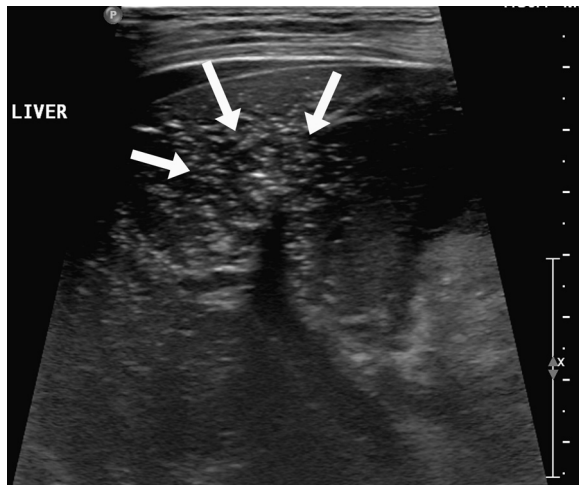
Transverse sonogram demonstrates a heterogeneous appearance of the liver with the presence of innumerable hyperechoic specks (arrows), suggestive of possible portal venous gas. Complex fluid collection was also noted (not shown).
